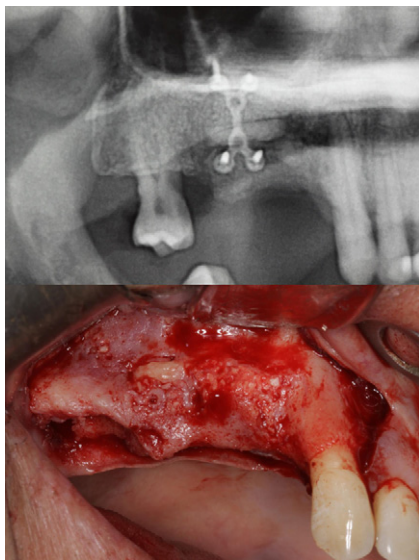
X-ray examination after 4 months showed satisfactory vertical gain and incorporation of the bone graft; gains in height and thickness of the alveolar ridge were confirmed during surgery.
